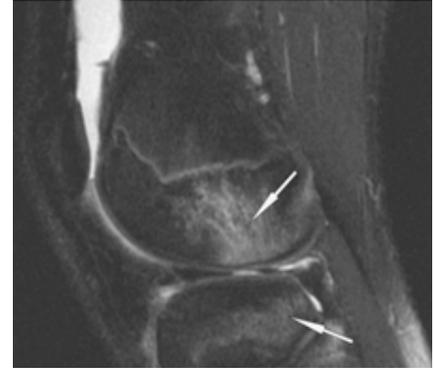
MRI scan documenting translational bone bruising associated with anterior cruciate ligament rupture.
